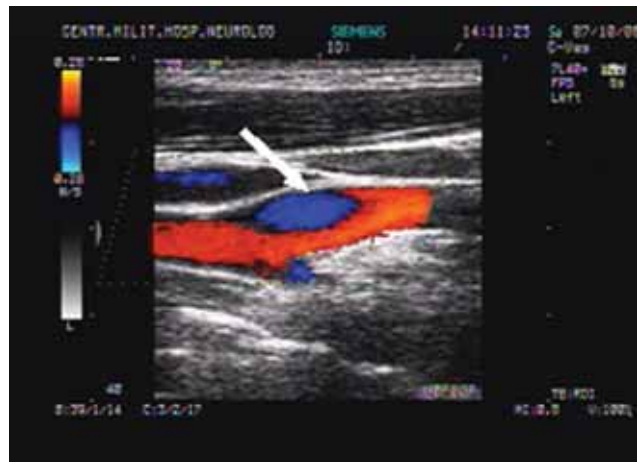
Echo – Doppler ultrasonography – color coded image shows two different blood flow patterns at the level of the internal carotid bulb – a faster one – specifically the main lumen and a slower one in the false lumen with backward flow in the internal carotid.
